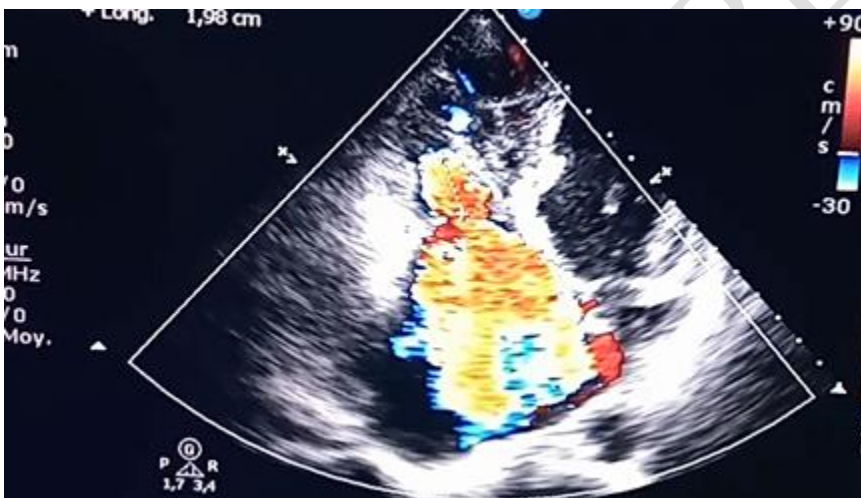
Apical four-chamber view showing dysplastic tricuspid valve with rudimentary posterior leaflet causing severe tricuspid regurgitation.
